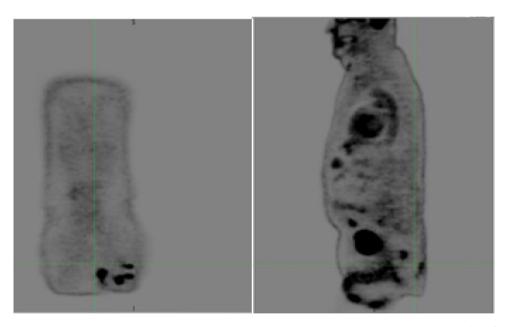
Images of the PET scan one month post-surgical excision showing largest masses measuring 2.3×1.8 cm and 2×2 cm with SUV max values of 13.3 and 10.4 respectively (4.13.15).
